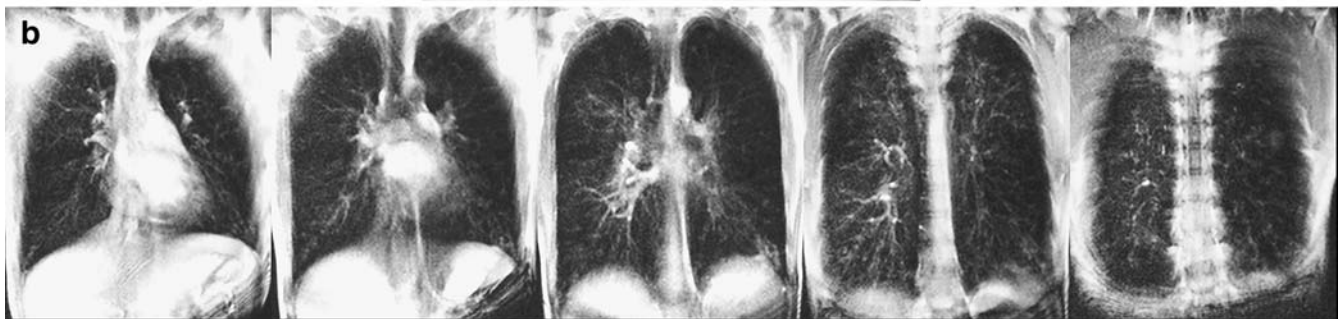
a Chest radiography (posteroanterior) of a 15-year-old female patient (Shwachman-Kulczycki score: 45, FEV₁: 30%, FVC: 39%) showing diffuse changes in the lung parenchyma with mottled shadows and bronchiectases particularly in the left lower quadrant.
